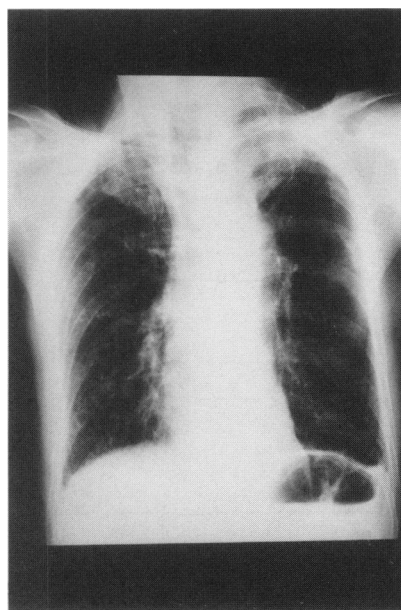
Postoperation chest X-ray.
